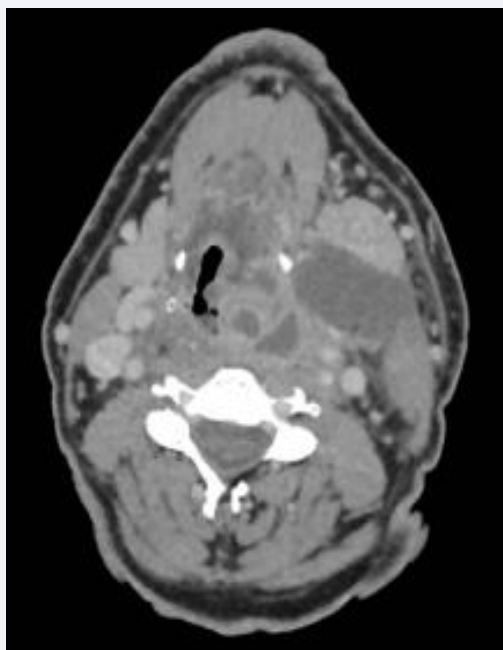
Axial computed tomographic scan showing the involvement of the left lateral pharyngeal space.
